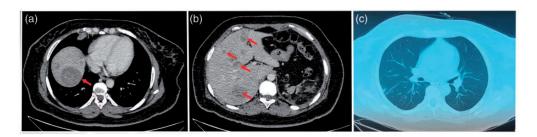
(a, b) Computed tomographic image shows multiple low-density areas, suggesting liver metastases before chemotherapy (arrow). (c) Computed tomographic image shows no significant metastasis in the lungs before chemotherapy.
